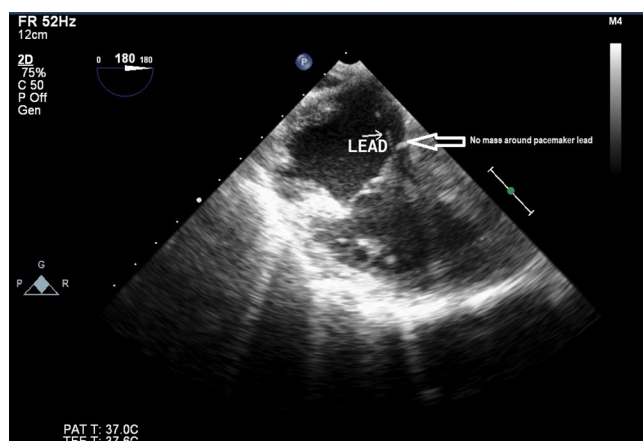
Echocardiography showing complete resolution of mass around pacemaker lead.
